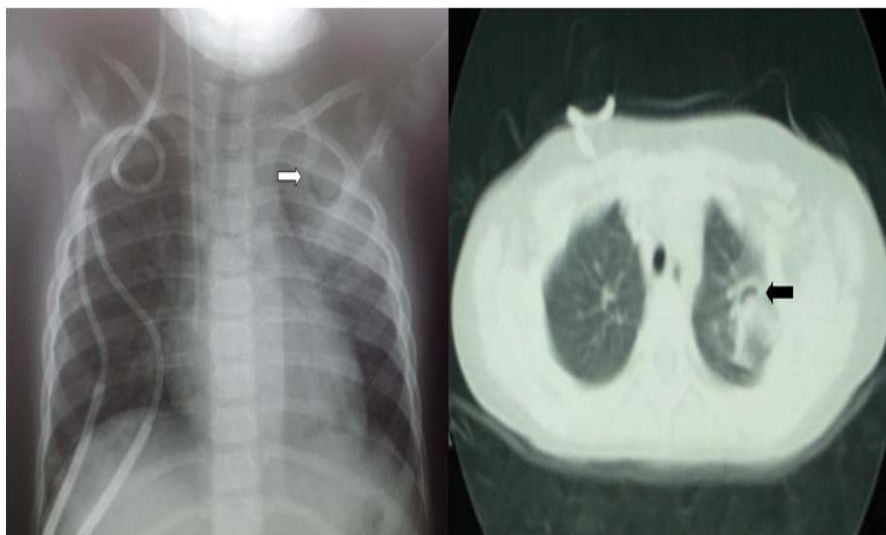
Chest radiography and CT scan of a girl with invasive aspergillosis
